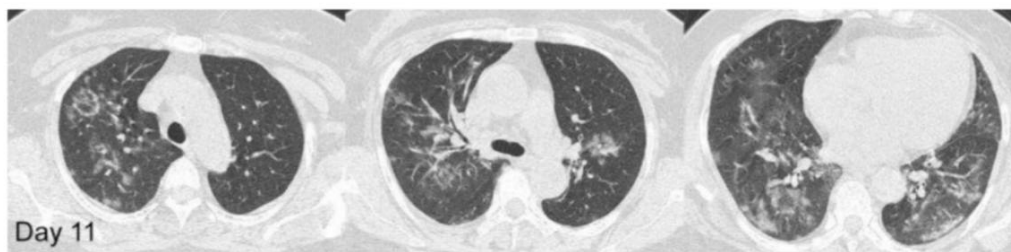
A follow-up CT on day 11, three days after initiation of antiviral treatment, showed significant improvement of the ground-glass opacities
